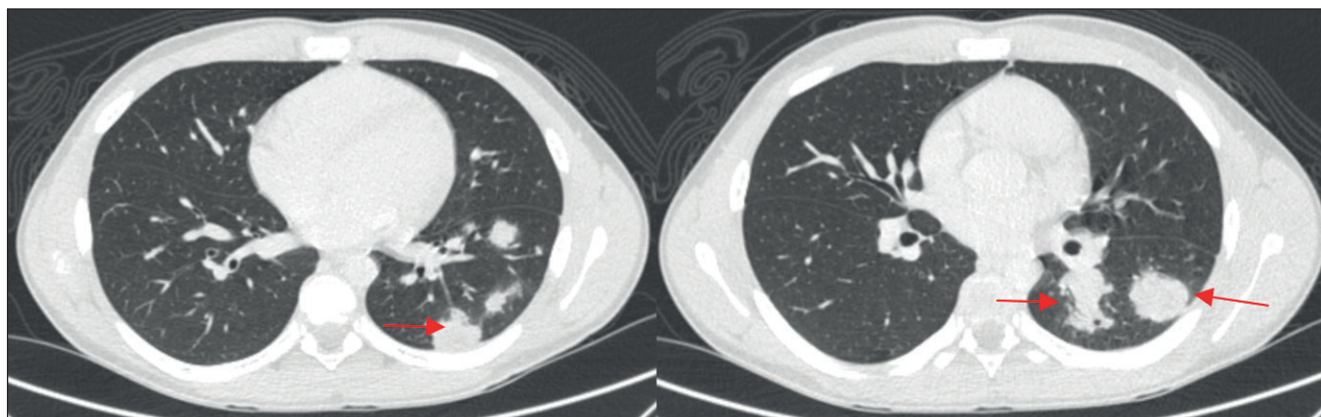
Initial CT scan: Multiple lung lesions of nodular appearance with lobulated borders in the left lower lung lobe.
